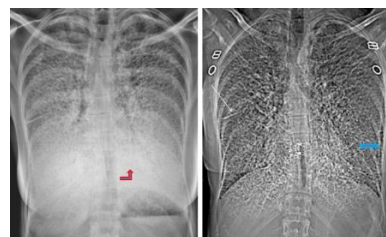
Fig 1a is frontal chest radiograph of a 20 y. female showing Snow storm / granular appearance of bilateral lung fields, mainly in bases with relative sparing the apices and stony lung at the bases (red arrow) Fig 1b is frontal CT scanogram image showing similar appearance, with more pronounced bilateral black pleural lines (blue arrow) and white fissural lines (white arrow).
